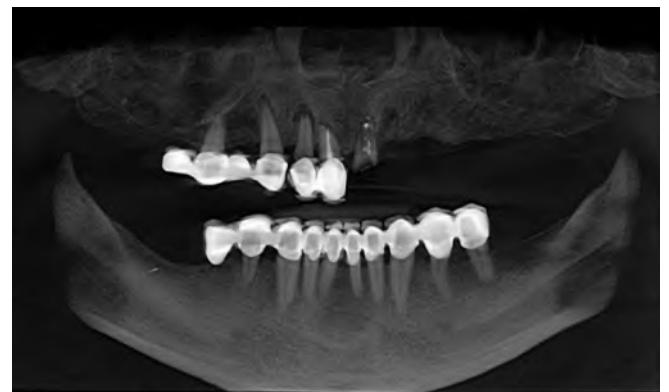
Pre-surgical CBCT images.
